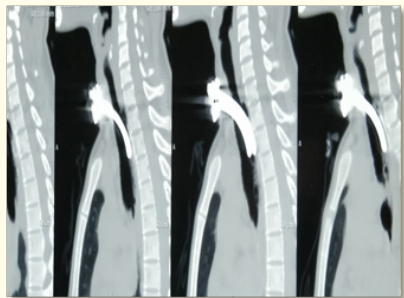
CT scan showing trachea-oesophageal fistula.
